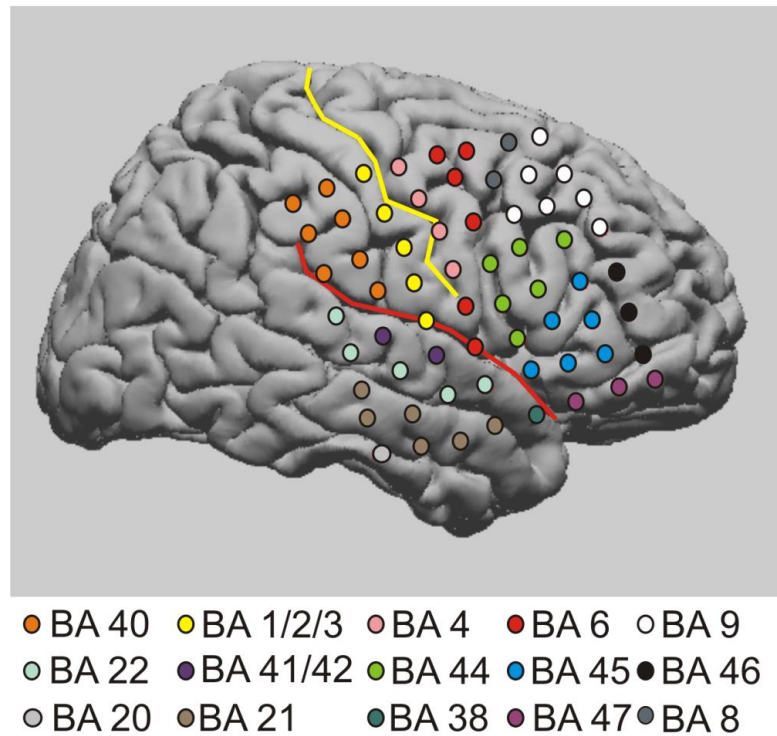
Localization of electrodes over the right fronto-temporal lobe in a representative subject. Electrodes are projected onto the MRI brain template used by the software package for the co-registration between the electrodes and the Talairach space (i.e. “Location on Cortex”, Miller et al., 2007). The colors of the electrodes code different Brodmann areas (BA).
